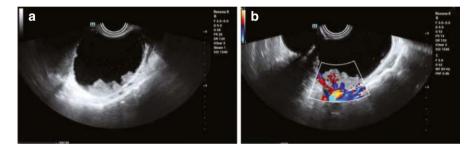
(a) B-mode ultrasound shows a papillary serous ovarian cystadenoma featuring medium-low echogenic papillary projections of varying sizes on the tumor wall. (b) Color Doppler ultrasound demonstrates blood flow signals within the solid projections
